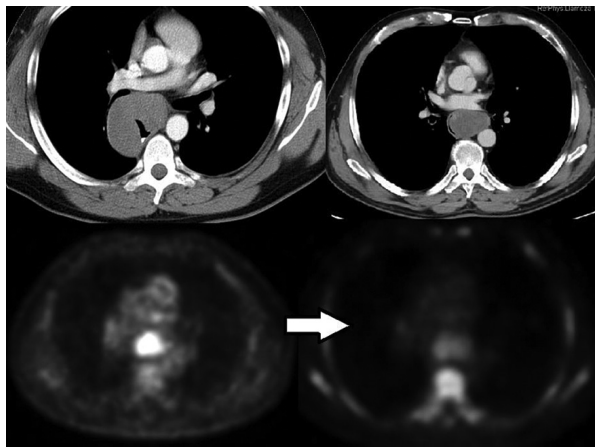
Computed tomography images showing discretely homogeneous space-occupying masses at the esophageal level.
